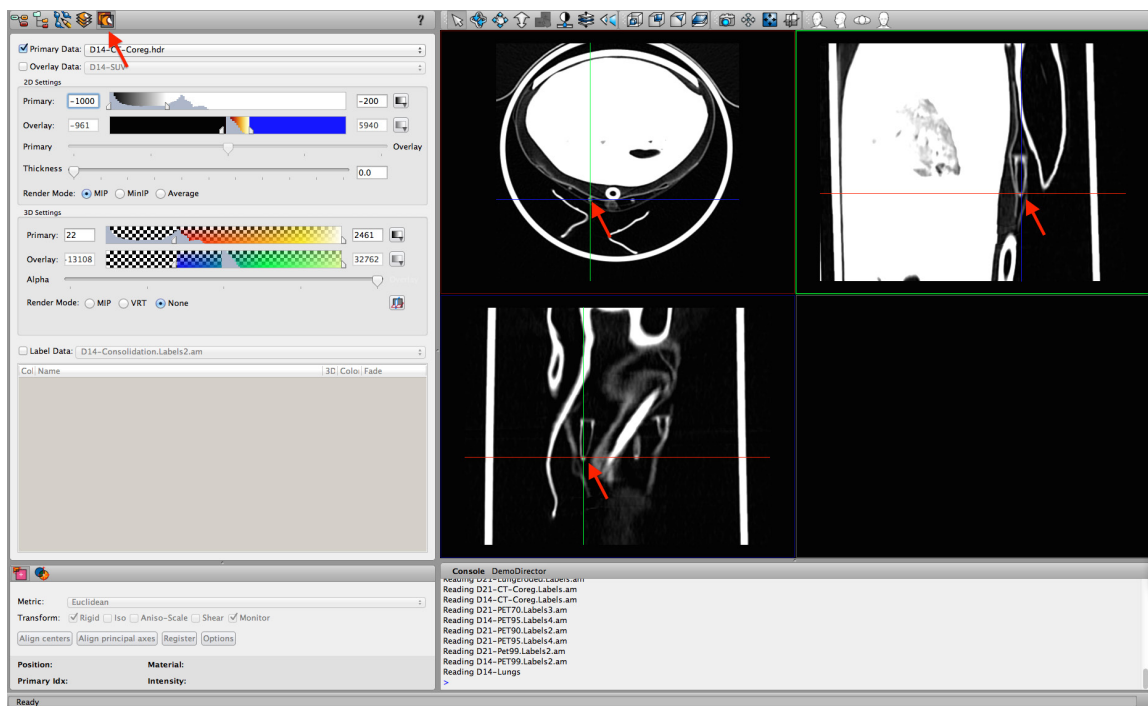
Amira CT point source
